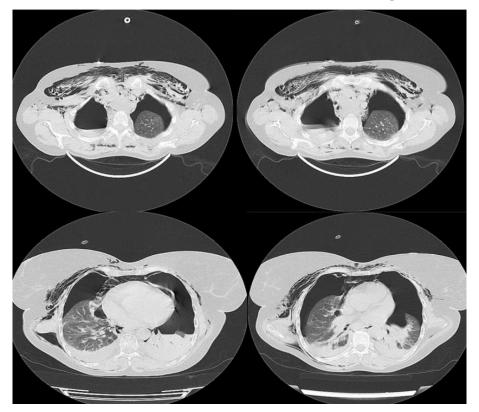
A chest CT of the patient showed severe bilateral collapse of the lung and bilateral hydrothorax, pneumothorax, Pneumomediastinum, extensive subcutaneous emphysema, and consolidation of the base of the lungs.
